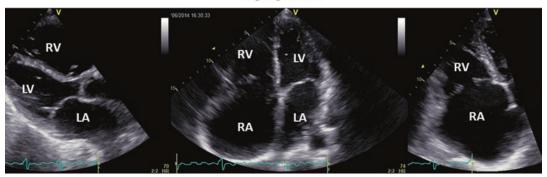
Right ventricular dilatation (left, parasternal long axis view; middle, apical four-chamber view) and right atrium dilatation (right, apical four-chamber view, zoom)
